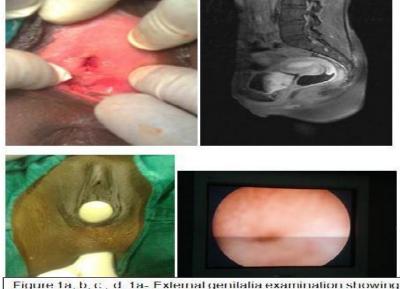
1a- External genitalia examination showing blind pouch below urethra 1b- MRI showing ballooned vagina opening into bladder. 1c- External genitalia showing fistula between rectum and blind pouch. 1d- cystoscopy showing vesicovaginal fistula opening in the bladder above bladder neck.
